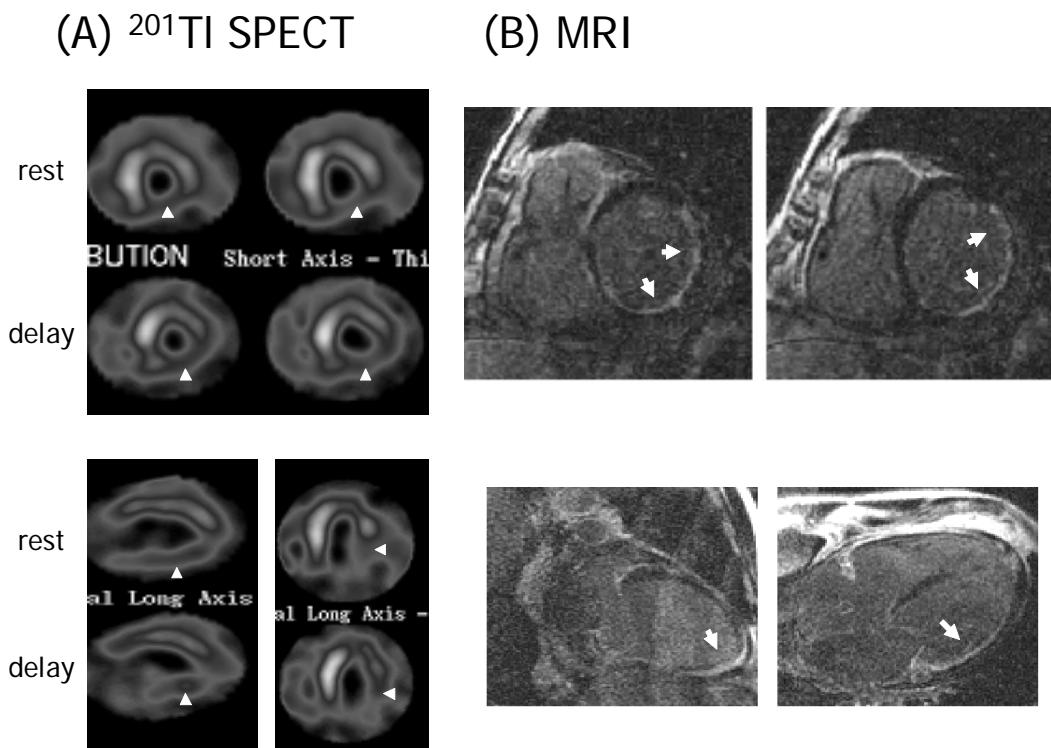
A 64-year-old patients with old inferior myocardial infarction (LVEF 17%) showed concordant scars in the inferior and inferolateral walls on the rest-redistribution  $^{201}\text{TI}$  SPECT (A, arrow heads) and delayed contrast-enhanced MRI (B, arrows)
